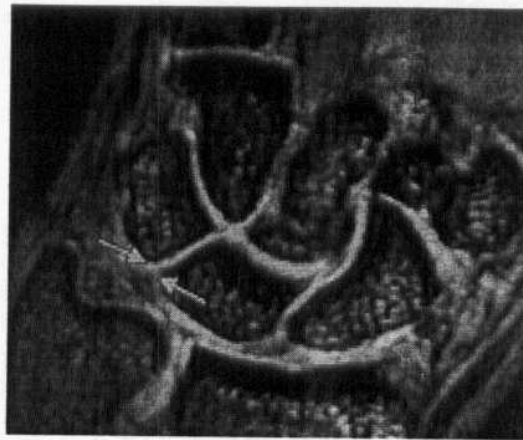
B) Images in two different patients with torn lunotriquetral ligaments. Unenhanced coronal three-dimensional gradient-echo MR image in a 46-year-old man demonstrates abnormal high signal intensity in the region of the lunotriquetral ligament (arrows) (Quoted from Haims, 2000).
